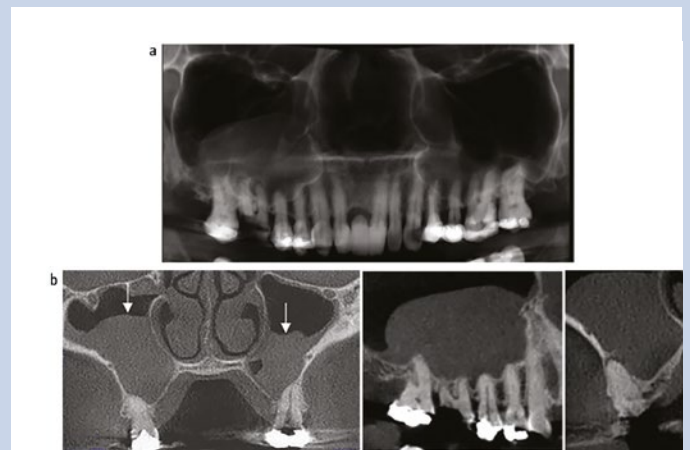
Case two, CBCT of a 60-year-old, planning for implant placement in the 16; 4b Coronal and sectional views show increase in the thickness and density of the tissues lining the maxillary sinuses, and a possible oroantral communication between the apex of the mesial buccal root of the 16 and maxillary sinus
